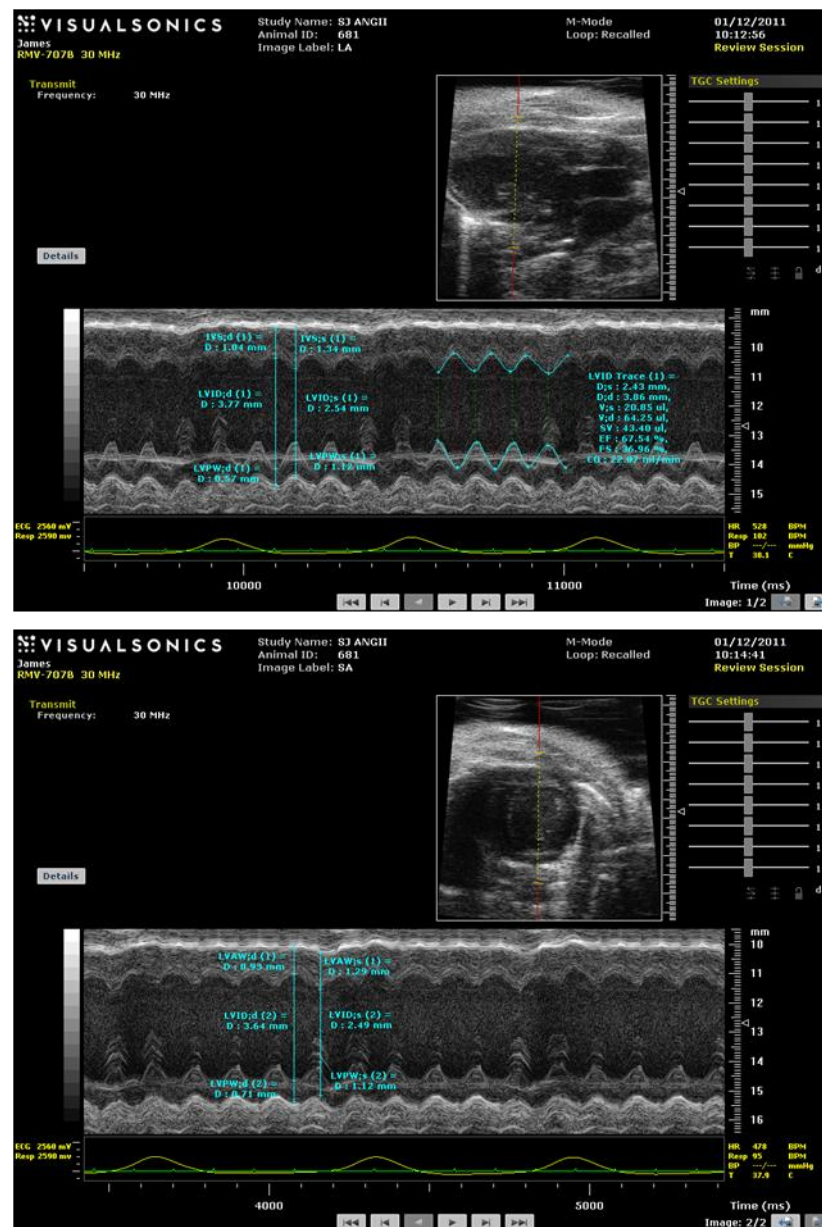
Echocardiography sample measurements. Views of measurements from long axis (top) and short axis (bottom).
